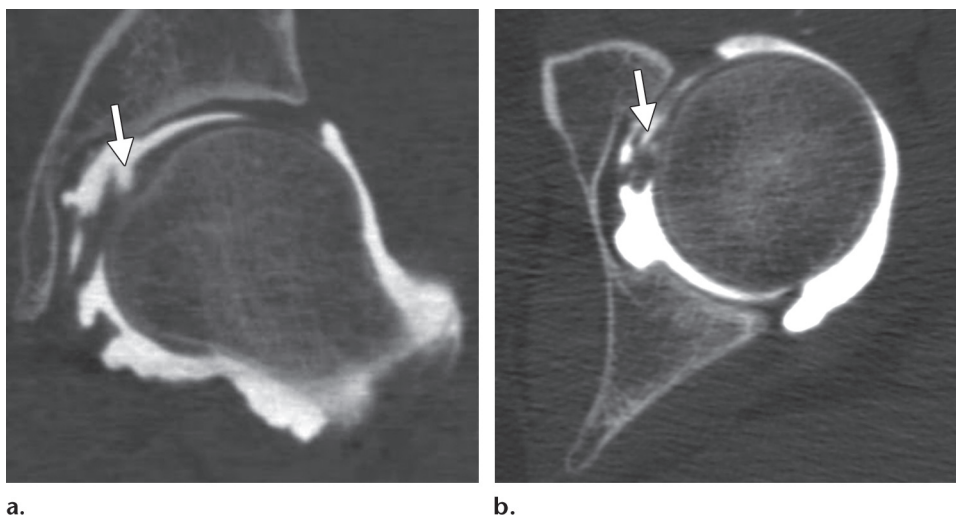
Partial tear of the ligamentum teres in a patient with a history of groin pain, catching, and locking. Coronal (a) and axial (b) CT arthrograms show extension of contrast material into the proximal part of the ligamentum teres and irregularity of the same part of the ligament (arrow), findings indicative of a partial tear.
